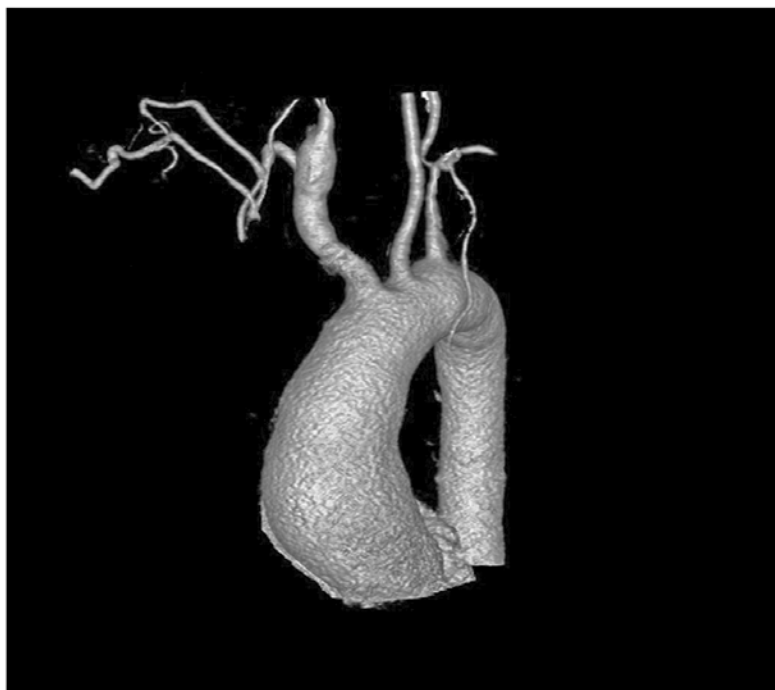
CT showing prestenotic dilatation of the right common carotid artery
